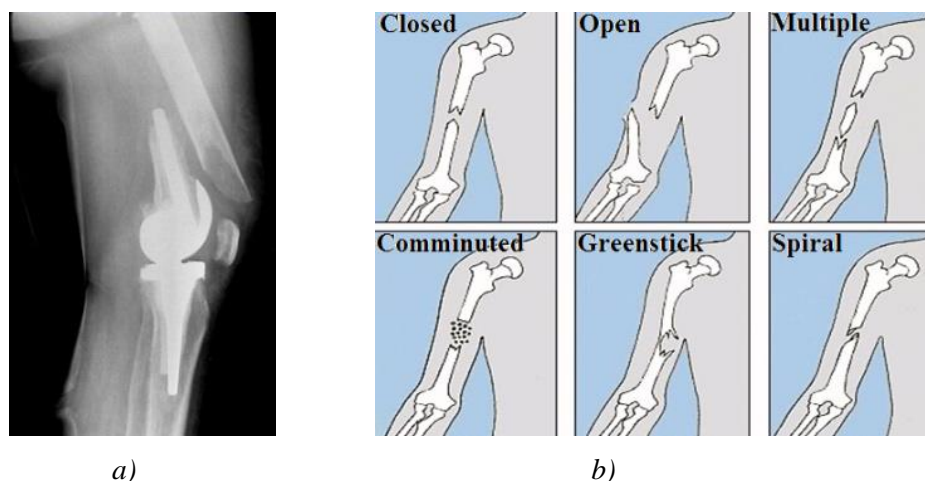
a) X-ray Rorabeck type II fracture (periprosthetic) – lateral view; b) Musculoskeletal fractures.
